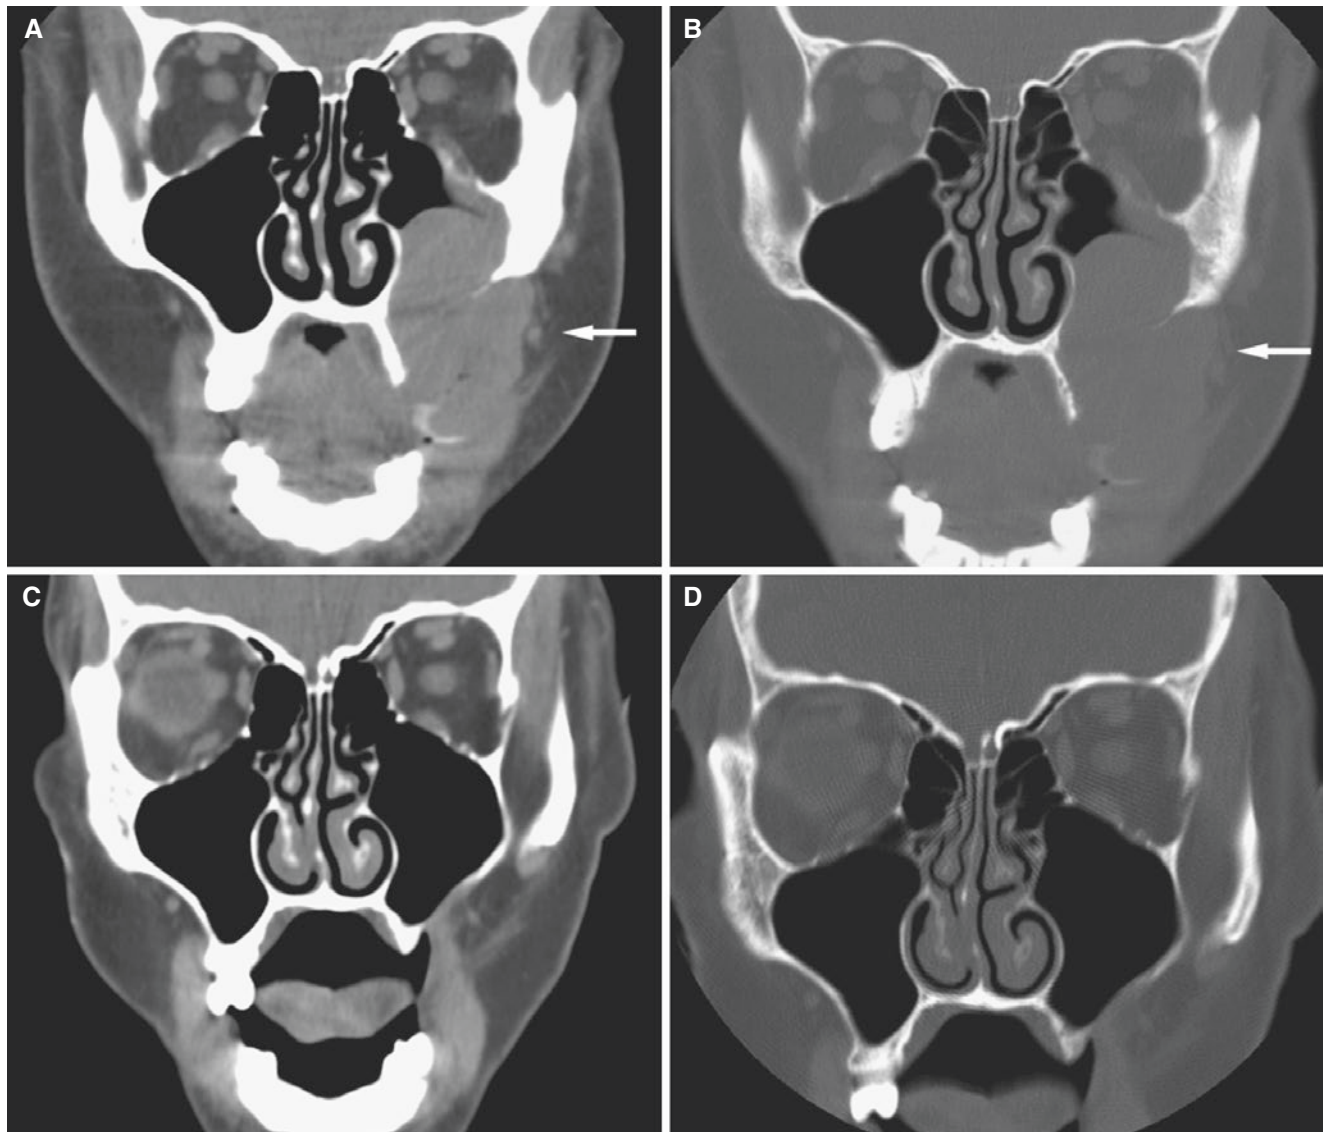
Maxillary plasmablastic lymphoma; 39-year-old male, HIV-positive status, presented with left facial pain and swelling. (A) Coronal CT image, soft-tissue window, shows soft-tissue mass in infra-temporal fossa that invades the left maxillary sinus with bone destruction (arrow). (B) Coronal CT image (bone window) shows severe
